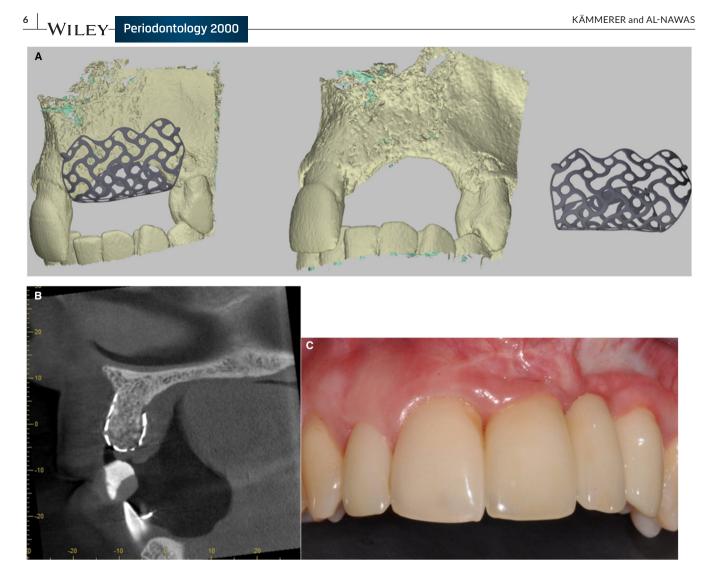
Mesh-based reconstruction of a mandible defect after resecting an odontogenic tumor. (A) Planning of a CAD/CAM titanium mesh; (B) CBCT after 6 months, before mesh removal and implant insertion; and (C) Final dental restoration. CAD/CAM, computer-aided design/computer-aided manufacturing; CBCT, cone beam computed tomography.
